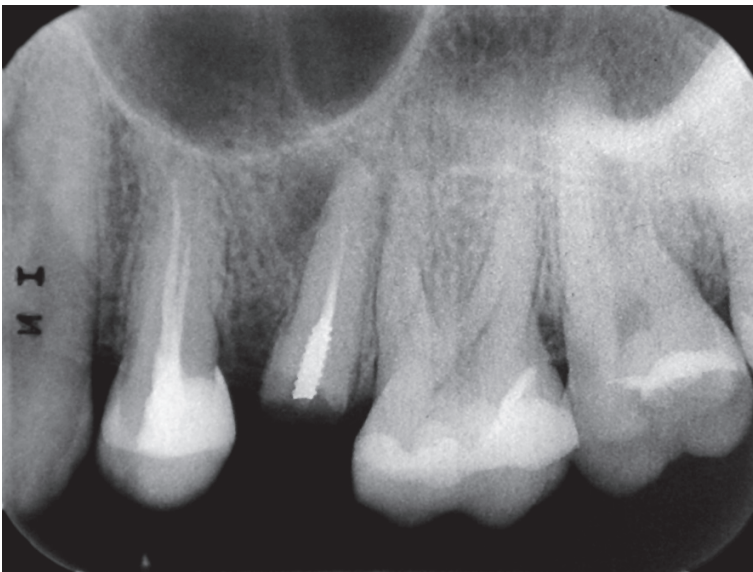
Radiographic tests.
